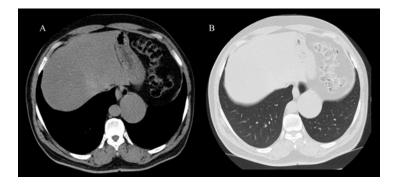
Previous non-contrast-enhanced axial CT images show a hypodense posterior mediastinal lesion in soft tissue window (a) and in lung window (b), which was confirmed to be a bronchogenic cyst.
